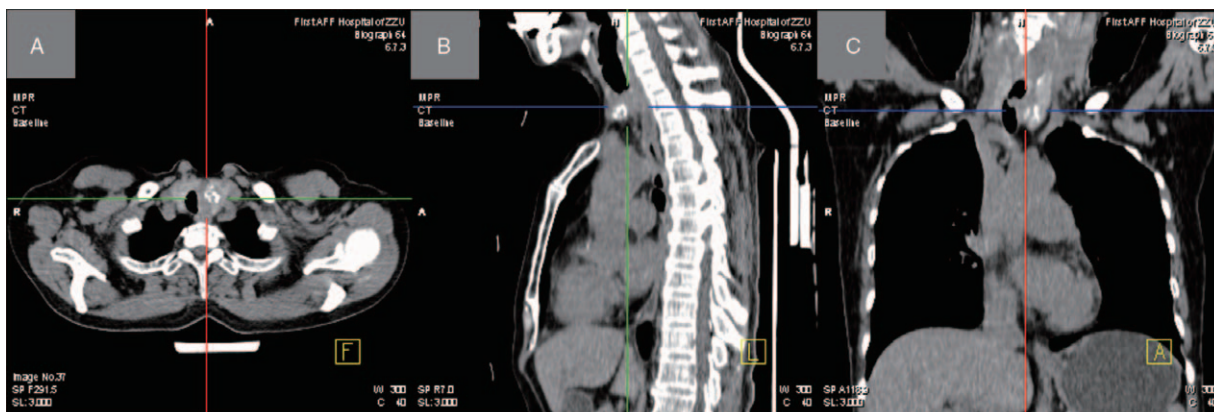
Thyroid computed tomography scan. (A) The axial image showed a well-defined calcified mass on the left lobe of the thyroid gland; (B) the sagittal image showed that the mass blocked most of the upper endoluminal trachea; (C) the coronal image showed a thickened area on the left side of the trachea and part of the mass protruding into the lumen.
